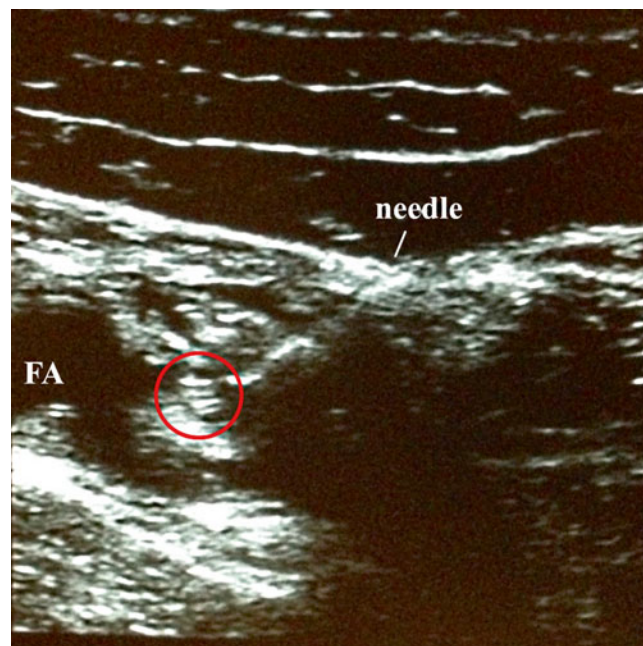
Ultrasound injection of the proximal saphenous nerve, using the femoral artery as a landmark, with the saphenous nerve circled. Note needle approaching from the *right*. FA femoral artery (Image courtesy of Agnes Stogicza, MD)
